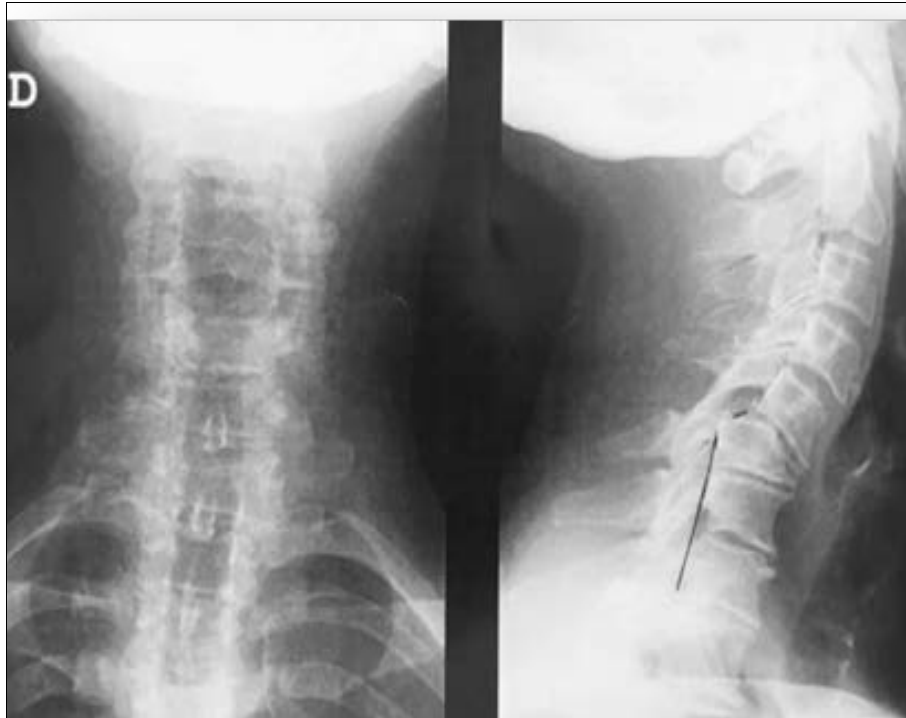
Cervical x-rays showing C5-C6 anterolisthesis
